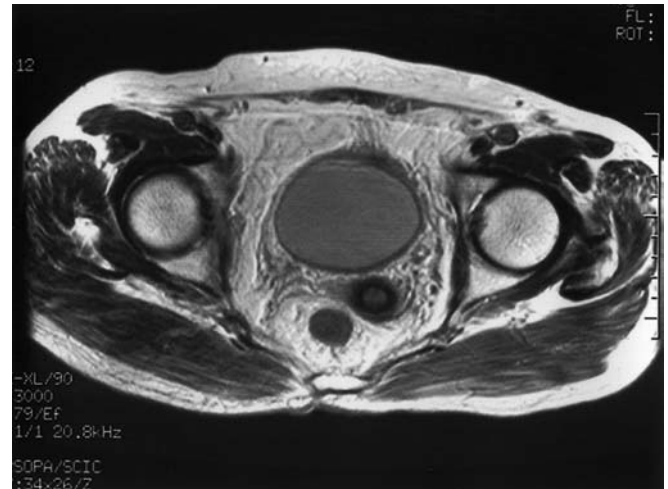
MRI after two courses of chemotherapy. No tumor was detected on the anterior wall of the bladder
